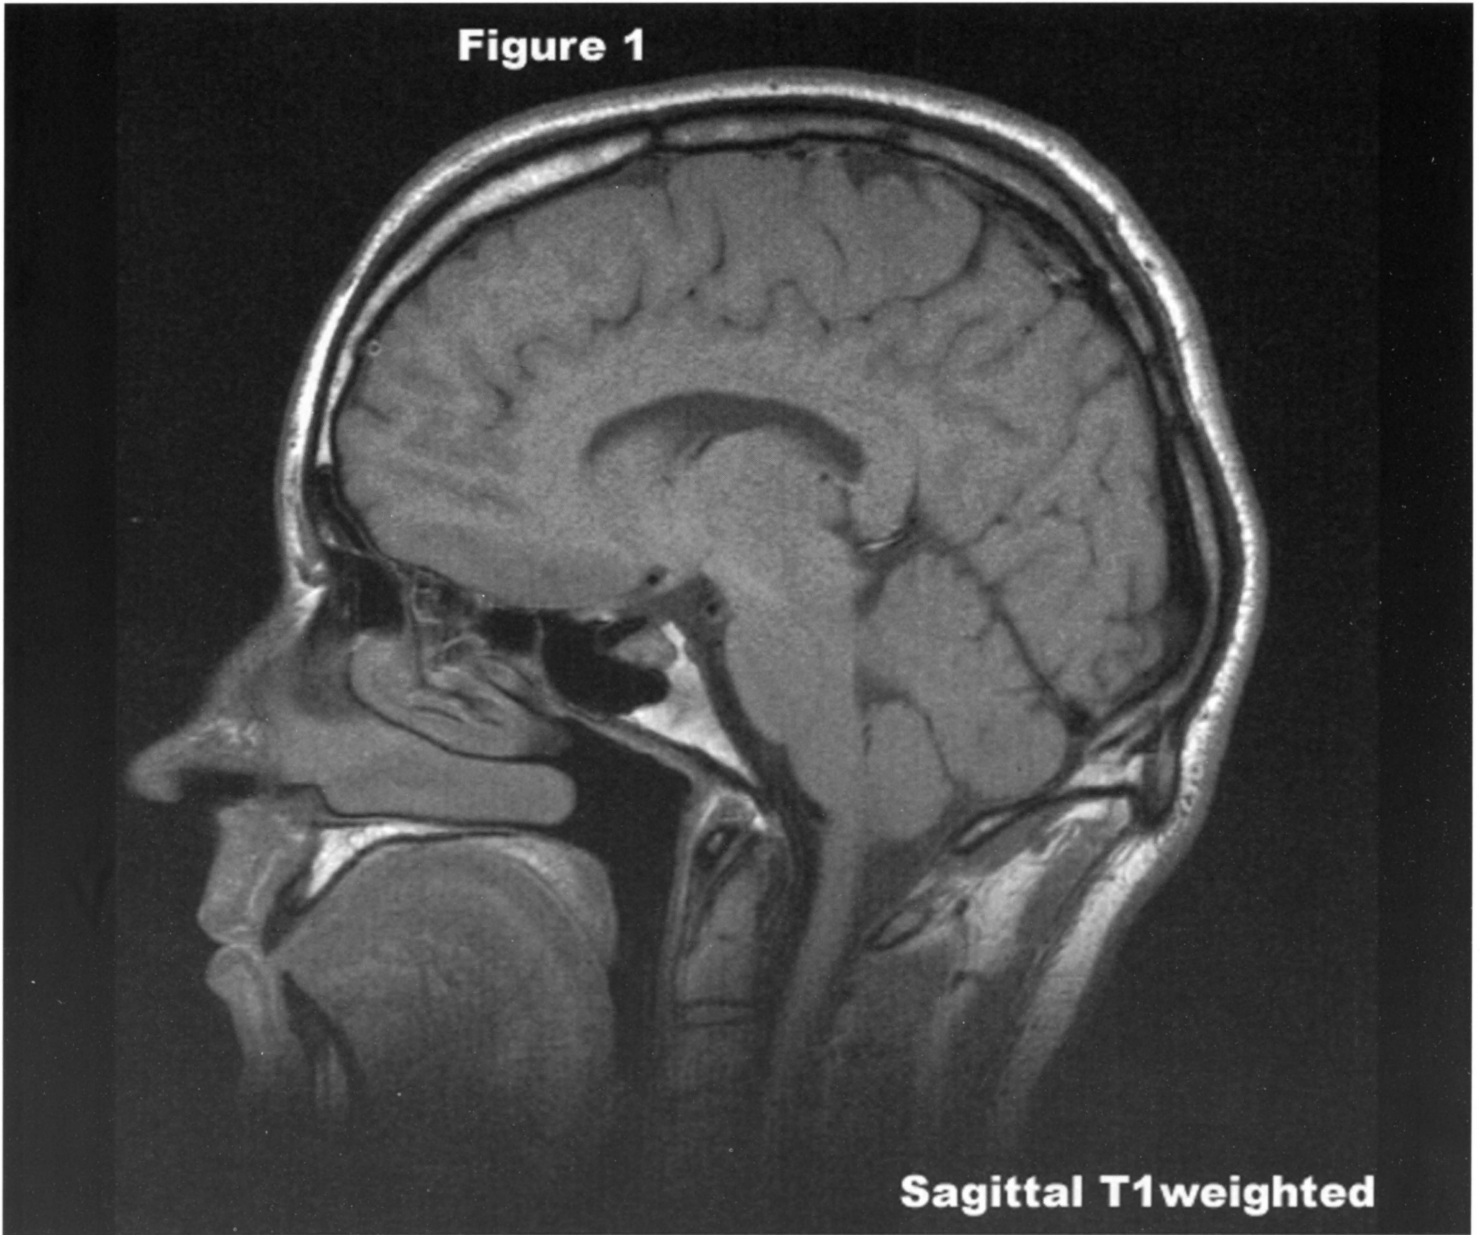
Midline Sagittal T1-weighted MRI
